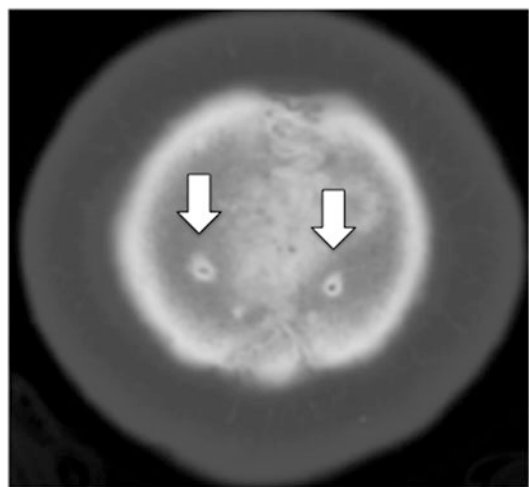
Normal parietal foramina. Axial CT through the vertex demonstrating small persistent biparietal foramina in an adult
